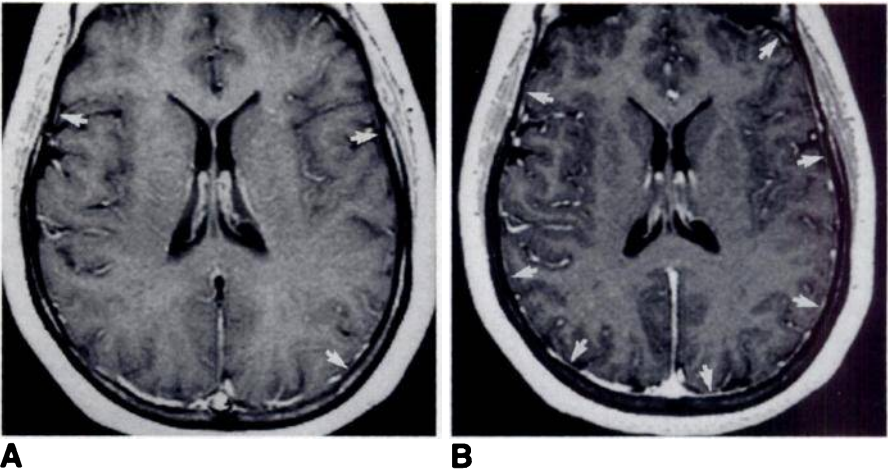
Corresponding contrast-enhanced 2DSE (A) and 3DGE (B) MR images at level of lateral ventricles (level three) of a patient with normal meninges. Short interrupted segments of meningeal enhancement are seen on 2DSE image (arrows), compared with more continuous enhancement throughout meninges on 3DGE image (arrows).
